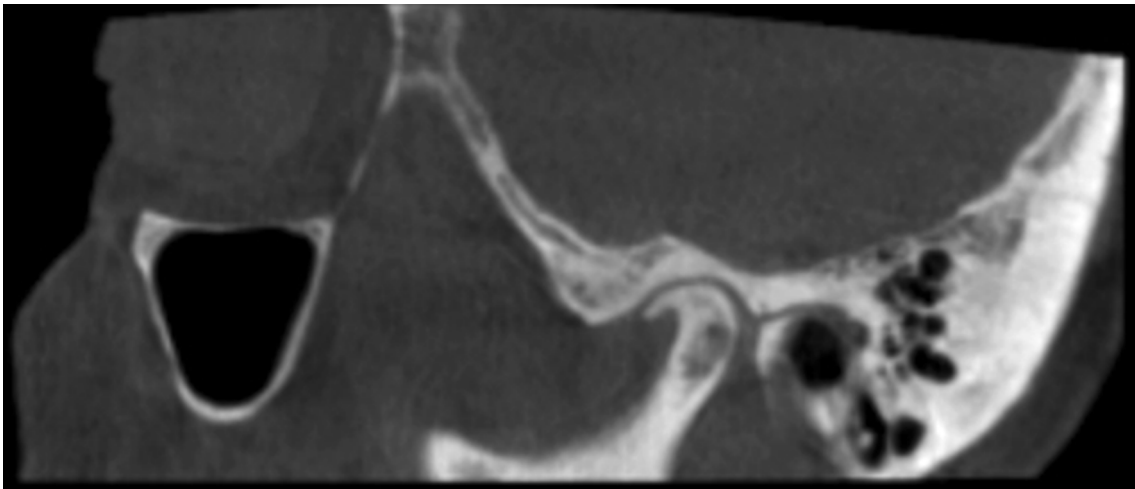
Female, 77 years. Oblique sagittal CBCT view shows deformed joint with condylar osteophyte and subcortical sclerosis in condyle and fossa, interpreted as osteoarthritis. CBCT, cone beam CT.
